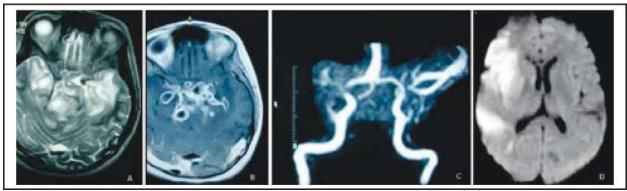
MRI-Brain of 18 year old girl.
